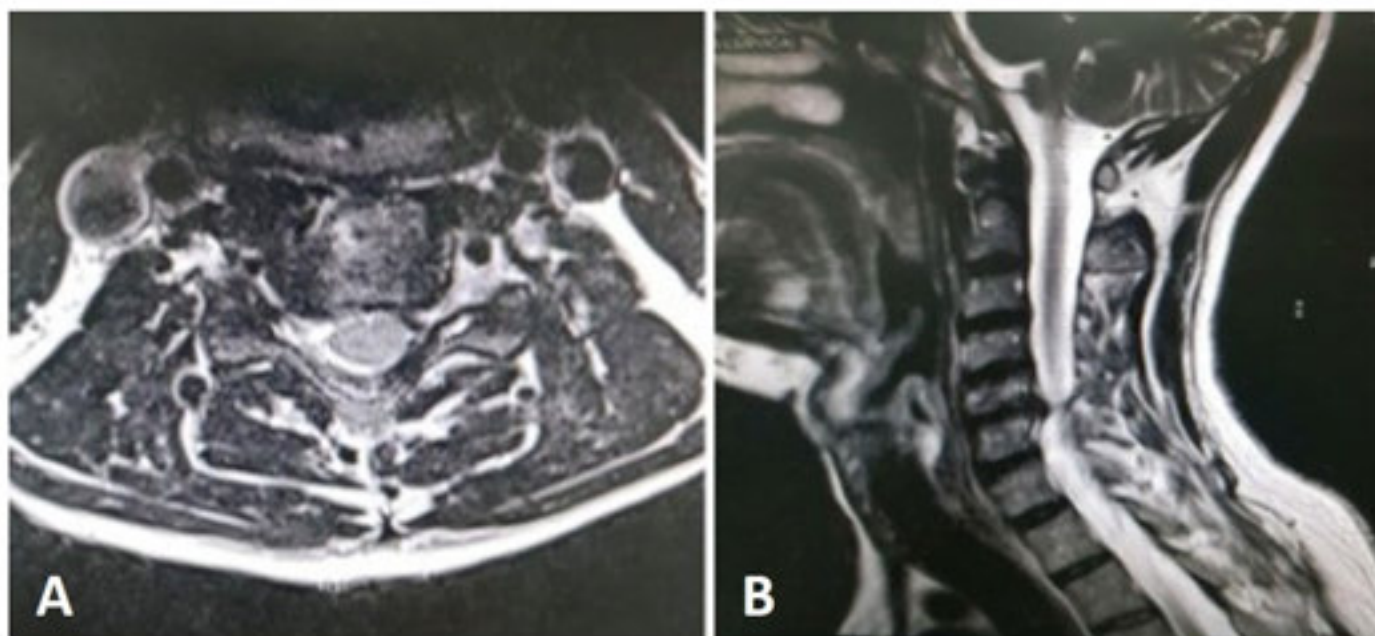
MRI of the cervical spine. A. Axial. B. Sagittal view confirming right-sided foraminal stenosis at C5-C6.
